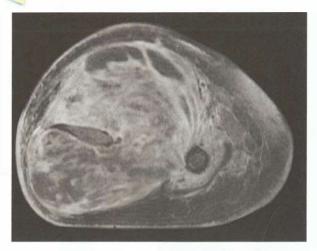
MRI of the thigh
